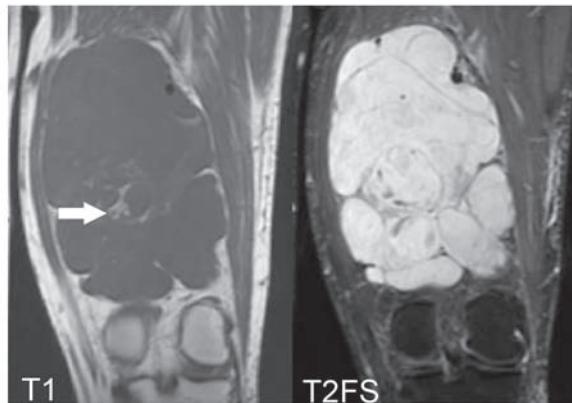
Lipomatous lesions. (a) Sagittal MR images show a large lipoma in the thigh. Note the fat signal intensity throughout the lesion on the T1-weighted image (left). The fat signal is completely suppressed on the T2-weighted fat-saturated image (right). (b) Coronal MR images show a large well-differentiated liposarcoma in the distal thigh. Note the large soft-tissue nodules (arrows) on the T1-weighted image (left). Signal from these nodules is not fully suppressed on the T2-weighted fat-saturated image (right). (c) Coronal MR images show a large myxoid liposarcoma in the distal thigh. The signal intensity of the lesion follows that of water: low on the T1-weighted image (left) and very high on the T2-weighted fat-saturated image (right). However, the lesion has internal complexity, with septa and focal nodular areas of fat signal intensity (arrow).
